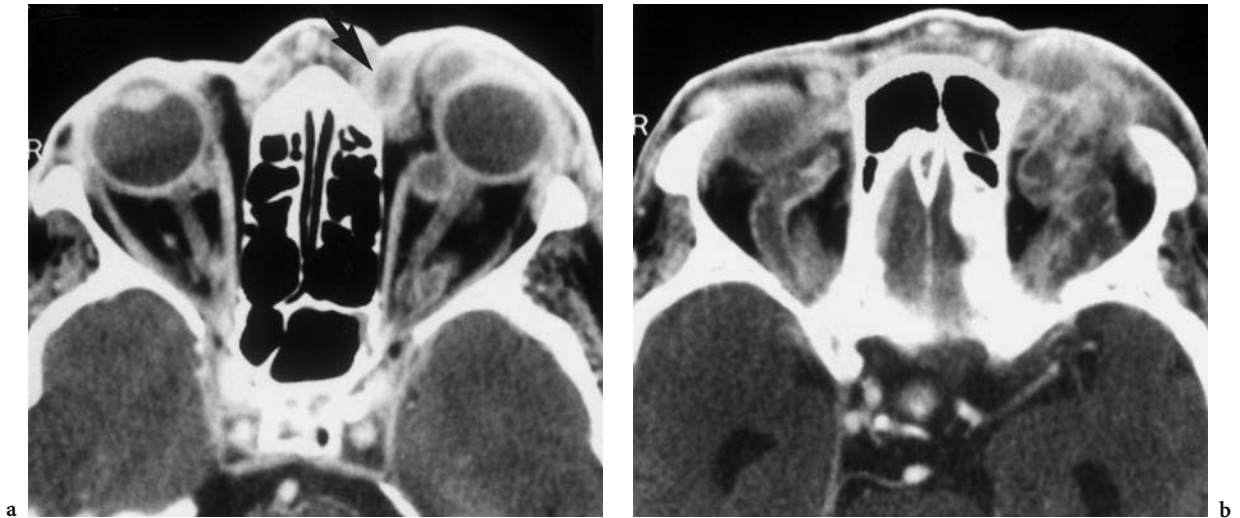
A 43-year-old woman with tongue and oropharynx carcinoma presenting in a febrile state with acute N III paresis and left-sided protrusion. Diagnosis: extensive thrombosis of the cavernous sinus and intraorbital veins. Axial contrast-enhanced CT: a Enlarged, sharply defined structures with central low density at the level of the optic nerve. The lesions are intraconal, extraconal, as well as preseptal (enlarged angular vein [arrow]). Note enhancement of both ICA in the hypodense, nonenhancing, but thrombosed cavernous sinus. b Involvement of both superior ophthalmic veins in the superior part of the orbit, the thrombi sparing the normal intravascular contrast (rubber phenomenon). (With permission of Dr. R. Gustorf-Aeckerle, Katharinen Hospital, Stuttgart)
